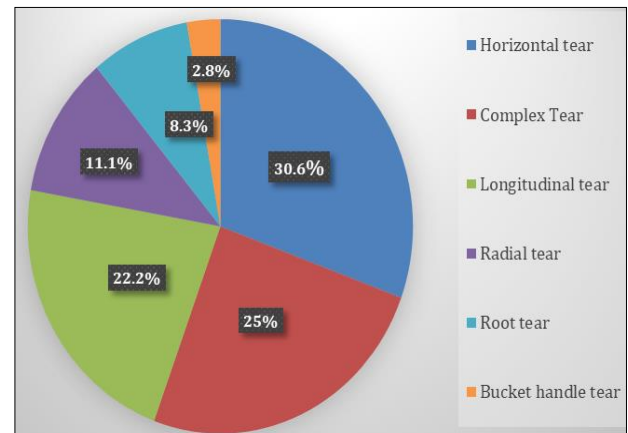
Number of patients with lateral meniscus injury on MRI
